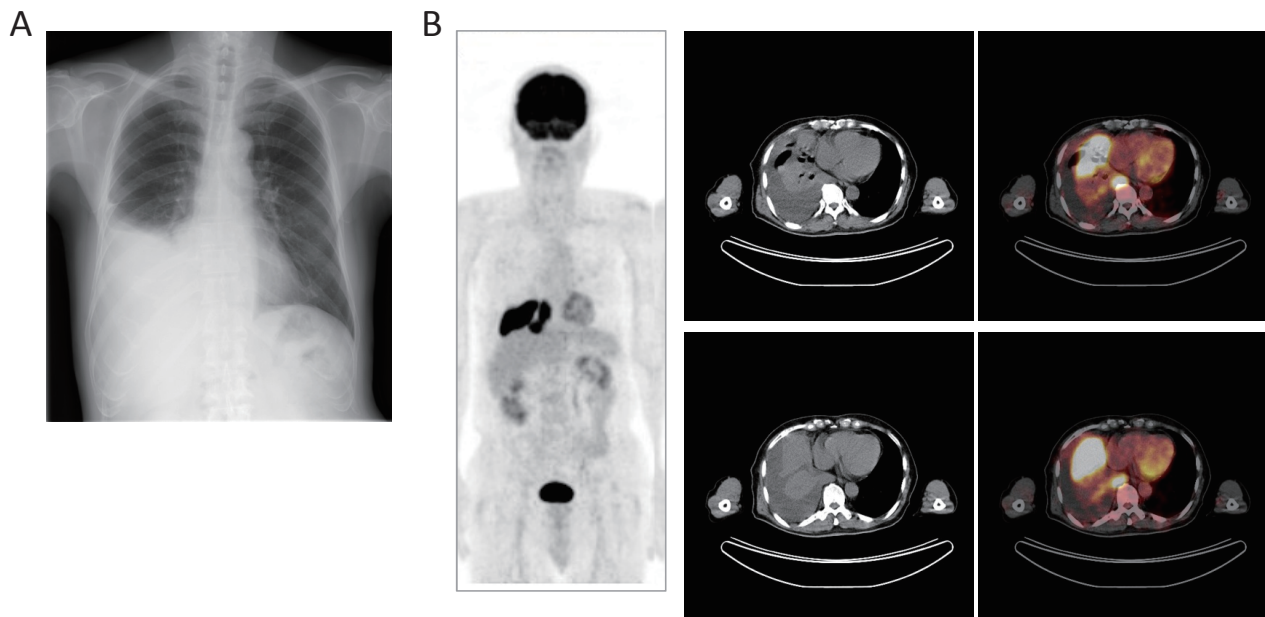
Imaging studies showing pleural effusion of the right thoracic cavity and an infiltrative condition of the lung parenchyma. (A) Postero-anterior chest X-ray. (B) FDG-PET/CT. The anterior view of a maximum intensity projection image (*left*) and representative axial images of the thorax (*right*) are shown. The maximum standardized uptake value of the pulmonary lesion was 17.89.
